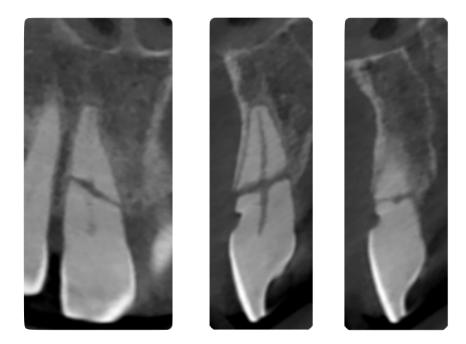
Pre-op axial CBCT x-rays. Root fractured of upper right central incisor.
